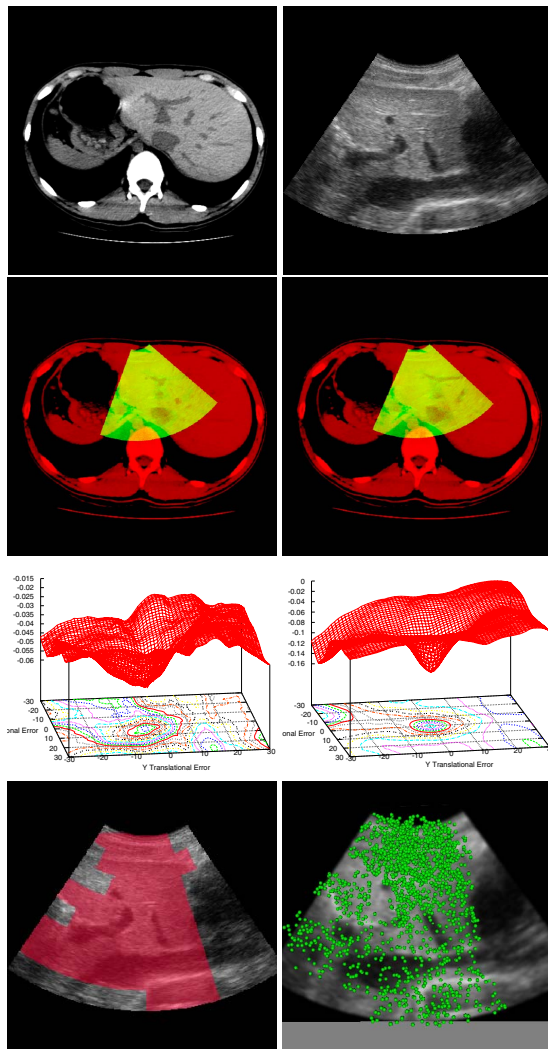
Registration results of US to CT patient liver by using MI and our proposed methods.
